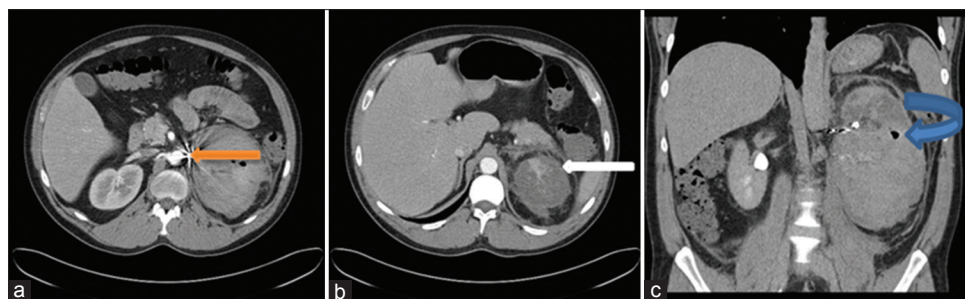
Postembolization computed tomography of the abdomen with contrast showing the positioned coil (orange arrow in 3a), almost complete left renal infarct with the left kidney replaced with heterogeneous mass in keeping with necrotic tissue and hematoma (white arrow in 3b). There are also locules of air seen centrally within the hematoma (shown by the curved arrow in 3c which may represent postembolization syndrome)
